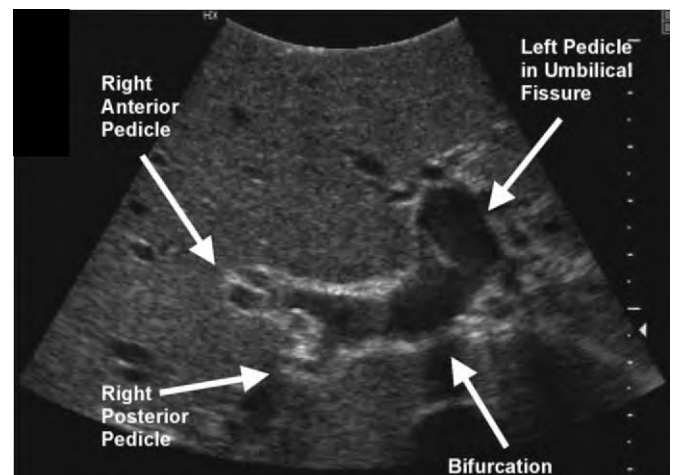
Intraoperative ultrasound image of bifurcation of the main portal pedicle into the right and left branches.
